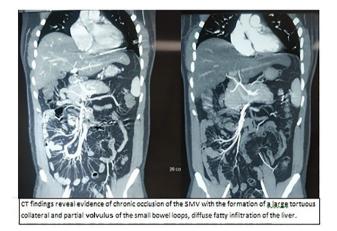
CT findings reveal evidence of chronic occlusion of the Superior Mesenteric Vein with the formation of a large tortuous collateral and partial volvulus of the small bowel loops, and diffuse fatty infiltration of the liver
